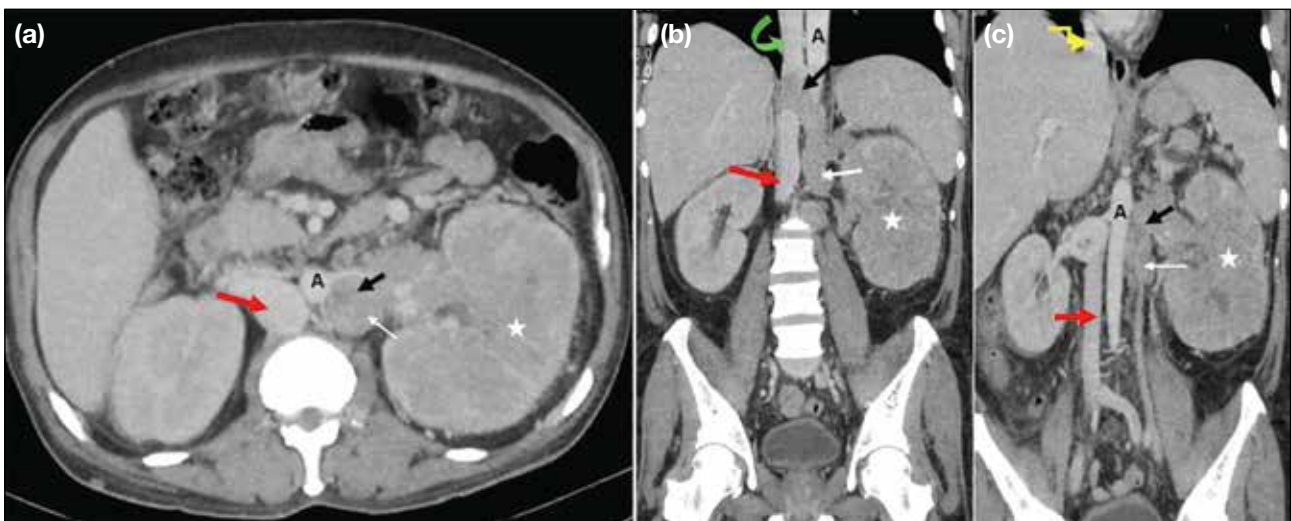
(a) Axial and (b, c) coronal contrast-enhanced computed tomography images of a patient with left renal cell carcinoma (stars) show a duplicated inferior vena cava (IVC) on either side of the aorta (A), with azygos continuation of the right IVC (red arrows). The left IVC (white arrows) crosses the midline and drains into the right IVC-azygos-superior vena cava pathway (green curved arrow in [b]). Tumour thrombus is present in the left renal vein and the left IVC, extending across the midline into the azygos continuation of the right IVC (black arrows). Hepatic veins drain separately into the right atrium (yellow elbow arrow in [c]).
